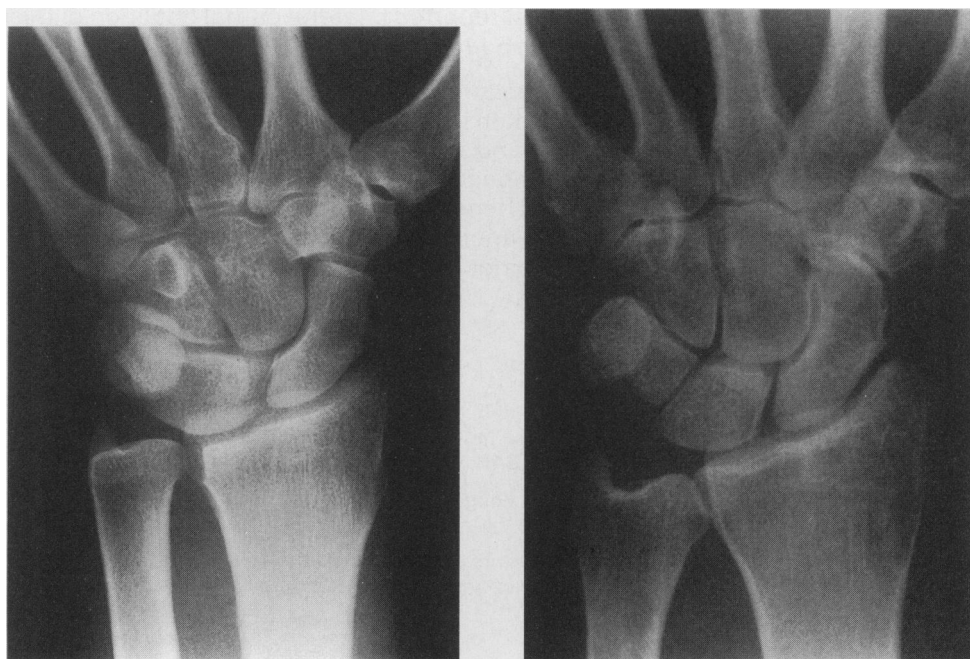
(a) PA radiograph of the left wrist showing lunate and triquetral coalition. The pisiform triquetral fusion was shown on lateral views. (b) Radiograph of normal carpal configuration for comparison.
